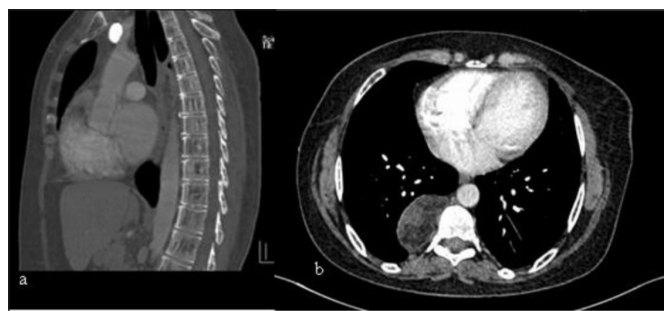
CT findings demonstrate well circumscribed, paravertebral thoracic mass, containing fat
